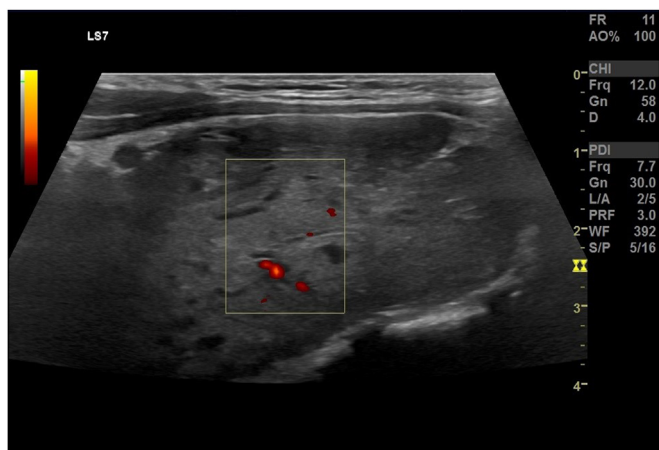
Color Doppler of preoperative paraganglioma on ultrasound.
